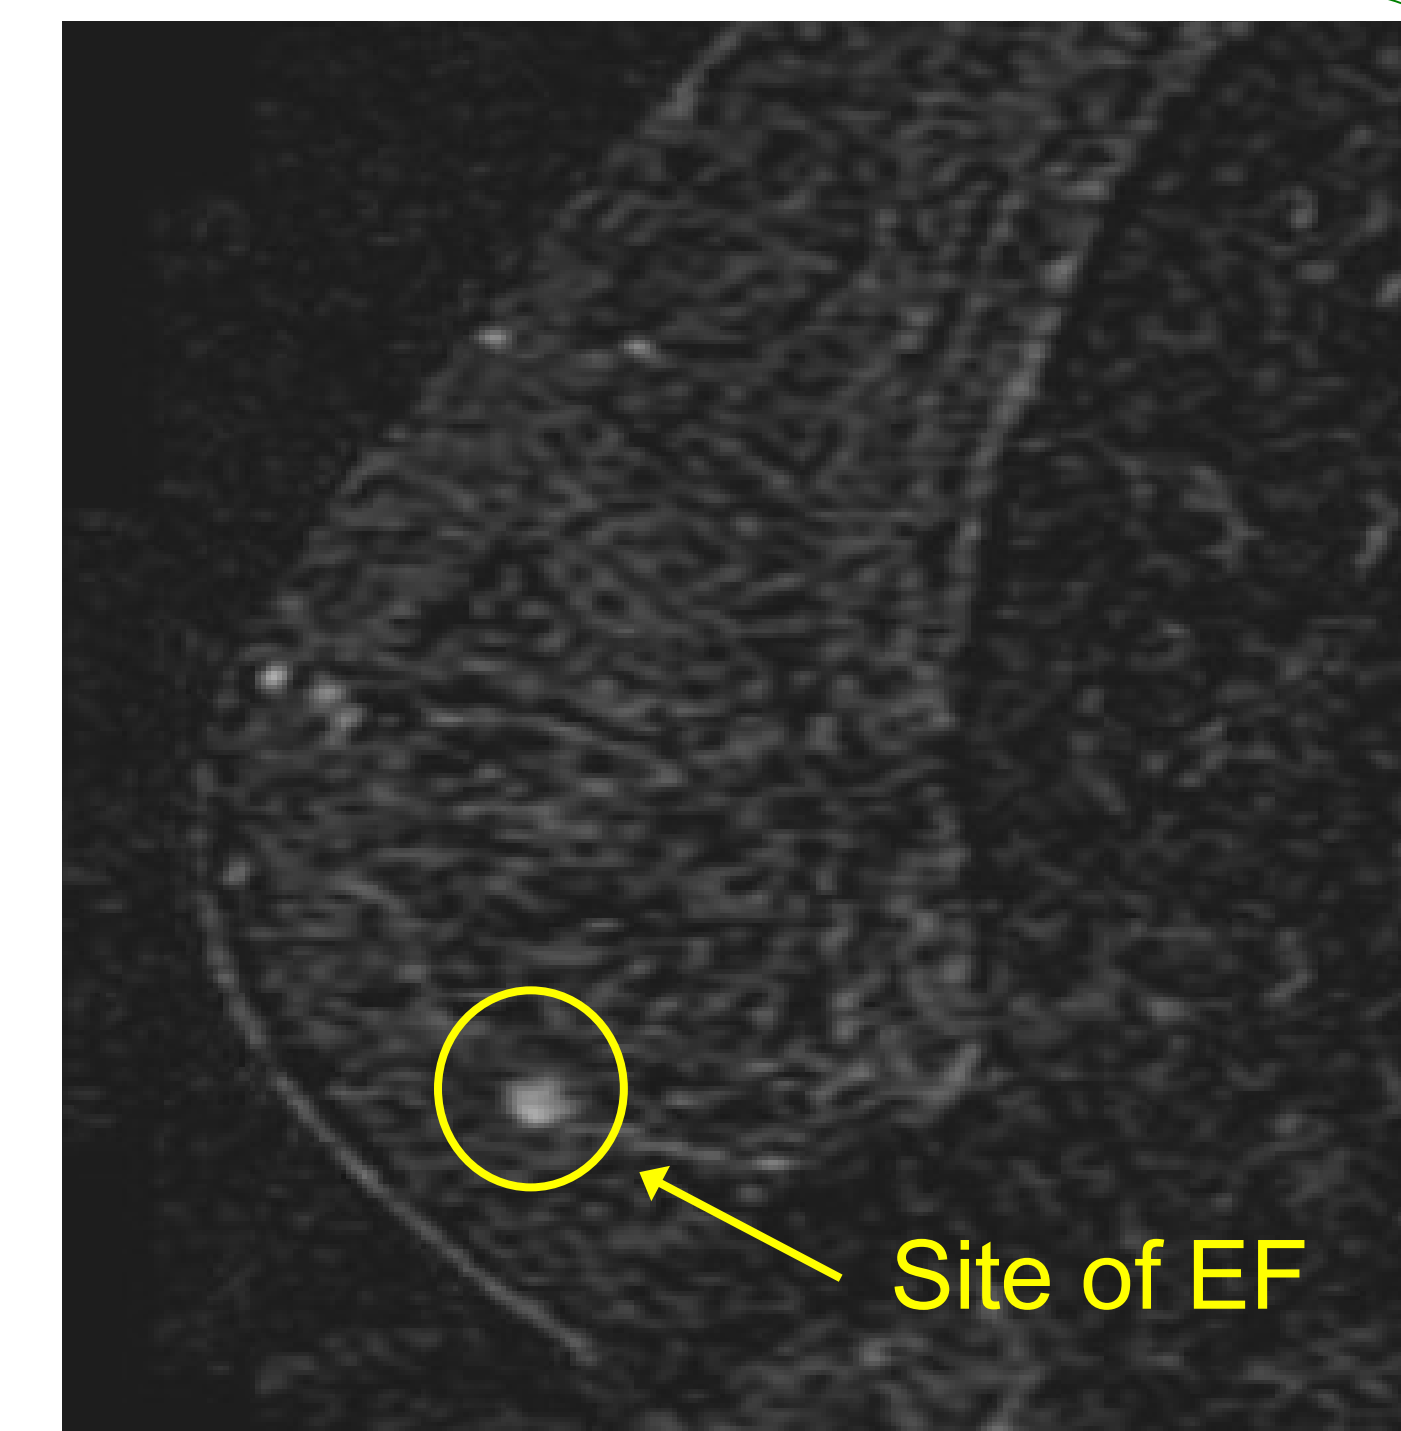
Digital subtraction MRI of right breast for Case 1
